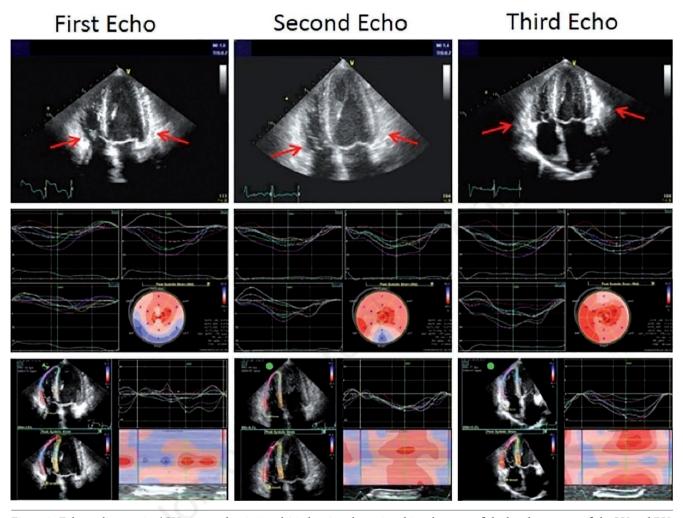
Echocardiogram in 4CH view at day 1, 7 and 21 showing the regional involvement of the basal segments of the LV and RV. The 2D strain of the LV and RV at day 1, 7 and 21 is represented.
